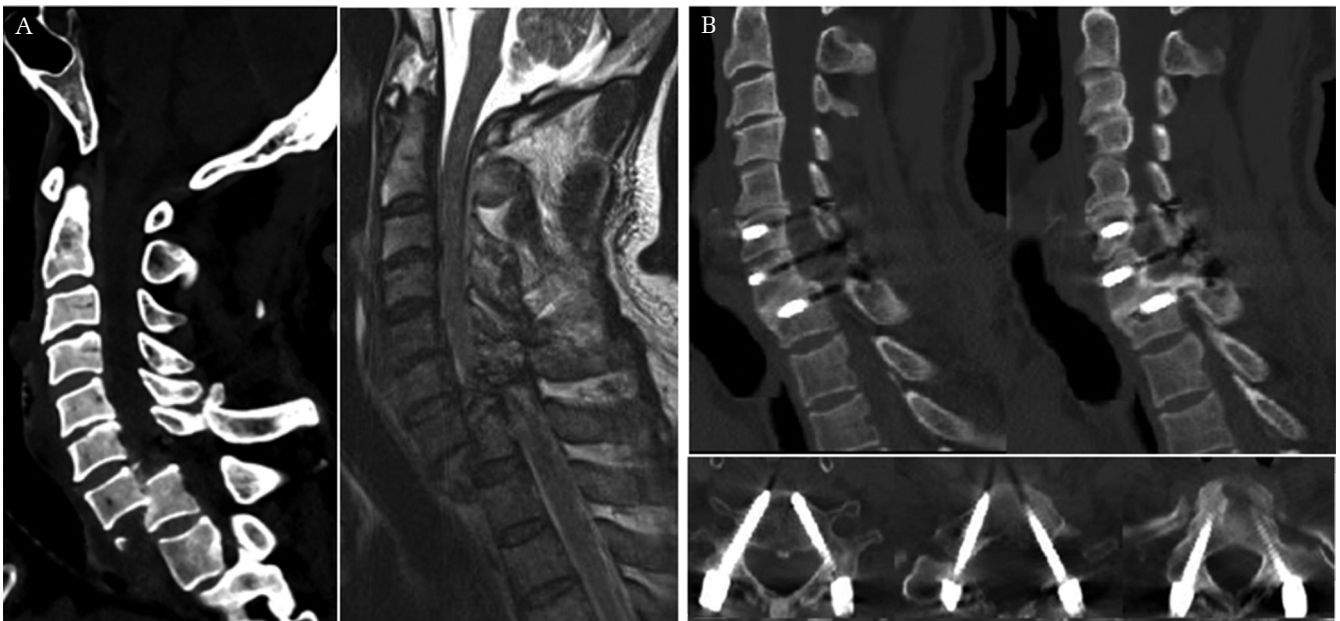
(A) Preoperative computed tomography (CT) sagittal and axial images showing complete dislocation of C7 vertebra from the T1 vertebra and indicating spondyloptosis on the C7–T1 level. T2-weighted sagittal MRI showing severe spinal cord compression, disc injury, and disc herniation on the C7–T1 level. (B) Postoperative CT images 1 year after the operation. In the sagittal image, the presence of bridging bone between C6 and C7, and C7 and T1 is seen. The axial view shows accurate screw position on the C6–C7–T1 vertebrae.
